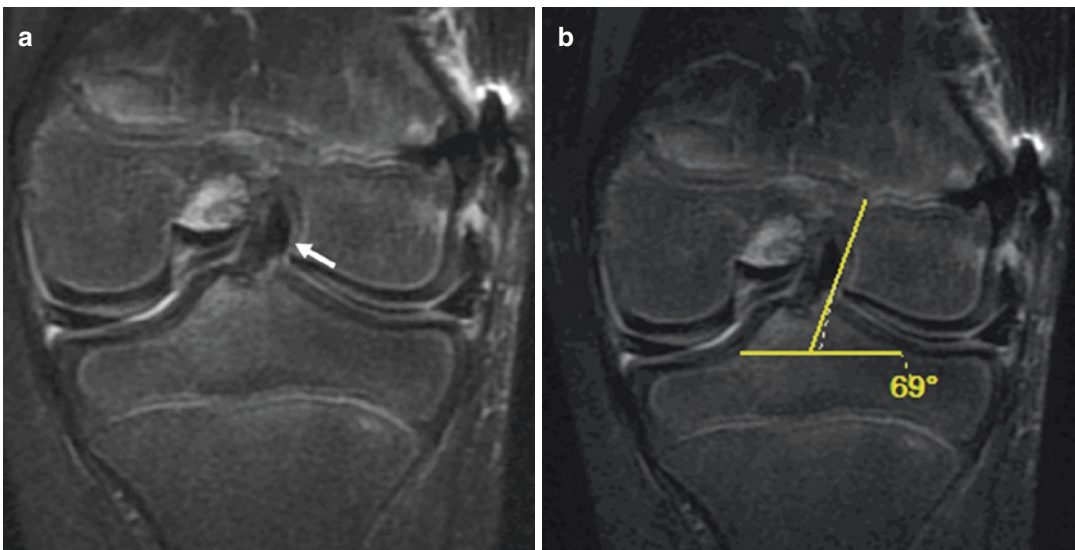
(a) Coronal T2-weighted fat-suppressed image of the left knee of an 11-year-old boy shows a normal-appearing hamstring graft exiting the femoral tunnel (*arrow*) and coursing into the intercondylar notch. (b)
